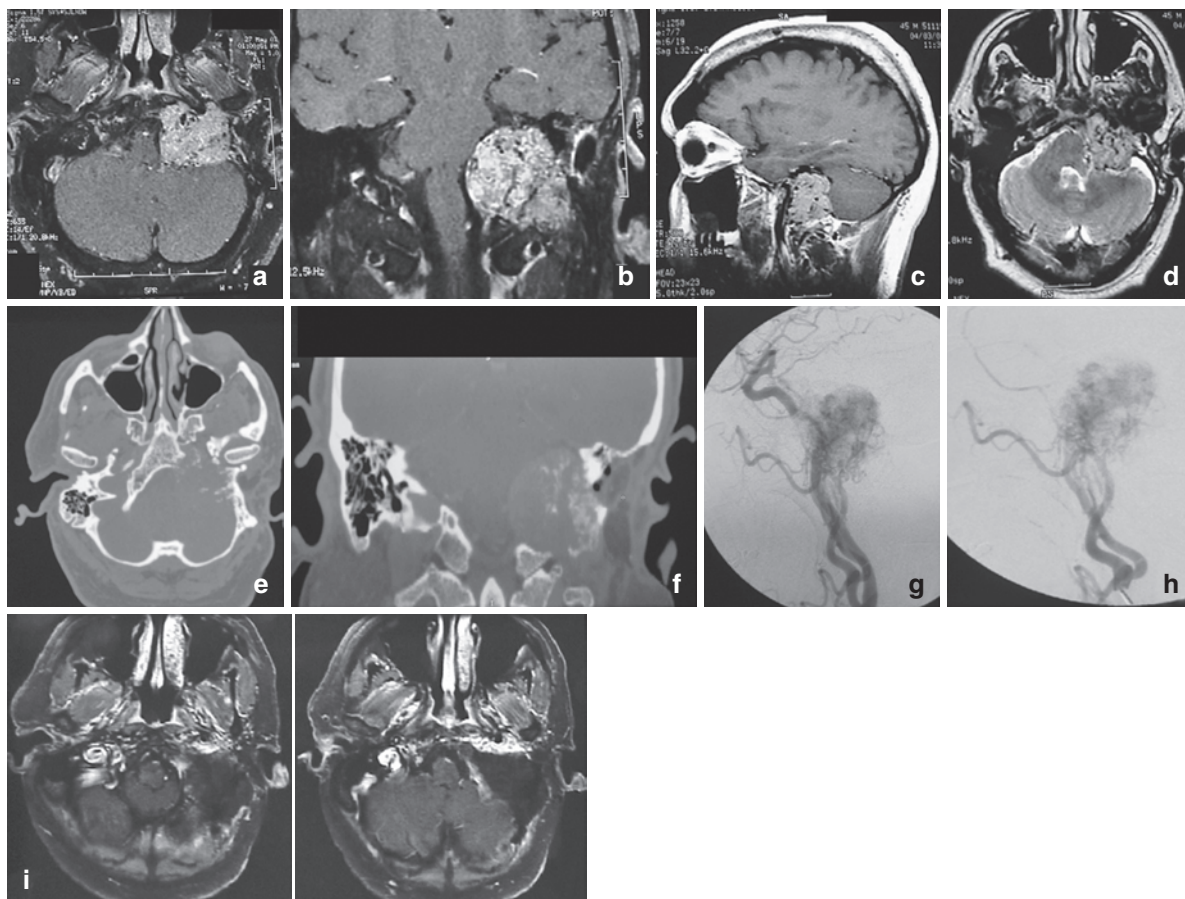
(a–i) Imaging of glomus jugulare tumors from one patient. (a–c) Preoperative postcontrast T1 imaging of glomus jugulare tumor in axial, coronal, and sagittal planes demonstrating heterogeneous contrast enhancement. (d) T2 MRI of glomus tumor demonstrating serpiginous dark regions corresponding to large flow voids. (e, f) CT scan in the axial plane
